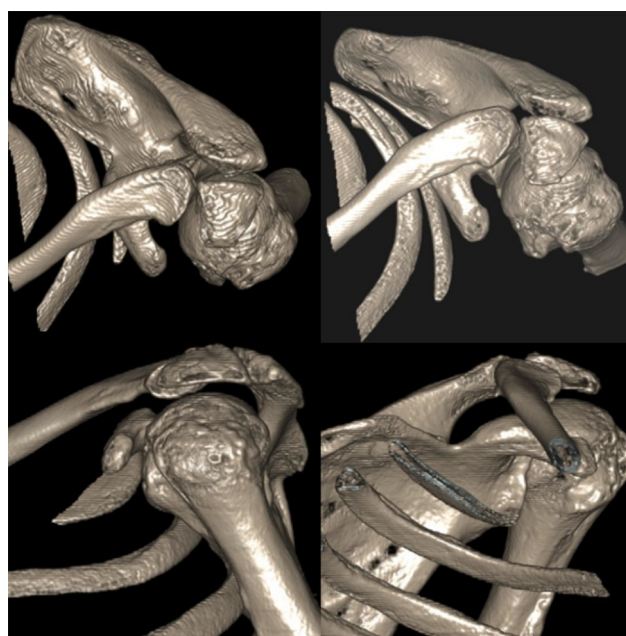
Preoperative shoulder 3-D CT scan show os acromiale.
